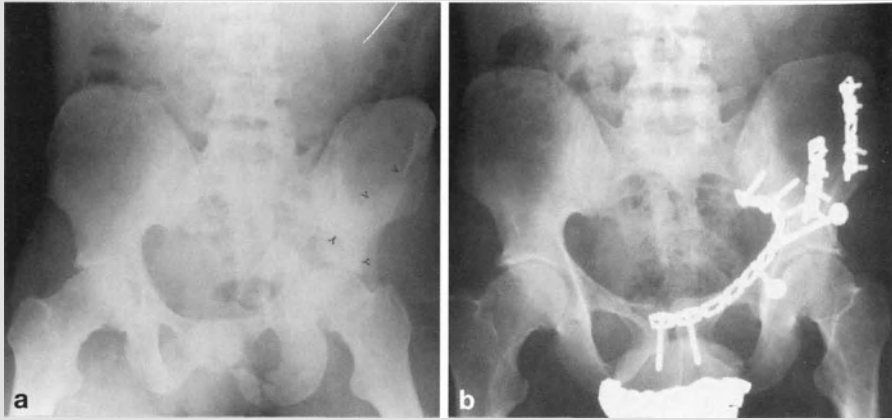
a AP pelvis in a 42-year-old man after lateral impact car injury. Central dislocation of the femoral head, comminuted acetabular fracture with central dislocation and tilting of the acetabular roof (*arrows*) and fractures of both rami pubis. The patient had no other injuries, was hemodynamically stable, and further examination revealed no bowel or urinary tract injury. A transcondylar traction was temporarily applied to the femur. b Internal fixation was planned on the basis of pelvic CT and performed 48 h later
